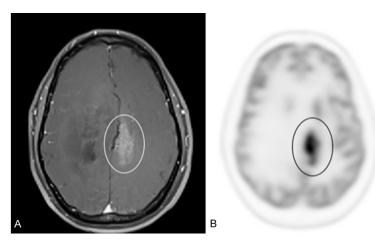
39-year-old male at the time of imaging with initial pathology of low-grade glioma localized to the right parietal lobe treated with resection. Approximately 10 years later, follow-up Gd-MRI (A) showed a new focus of enhancement in the cingulate region contralateral to the treated lesion, which was suspicious for a recurrent high-grade anaplastic oligodendroglioma (white oval). FDG-PET scan (B) demonstrated an extremely hypermetabolic focus (SUVmax = 27.7, SUVmax/WM = 10.26) corresponding to the enhancing lesion on MRI (black oval). These values are consistent with recurrent high-grade tumor recurrence. Subsequent biopsy revealed malignant degeneration of the initial lesion to anaplastic oligodendroglioma. Despite the high FDG uptake the patient was still alive at the completion of our study, 87 months following the FDG-PET.
